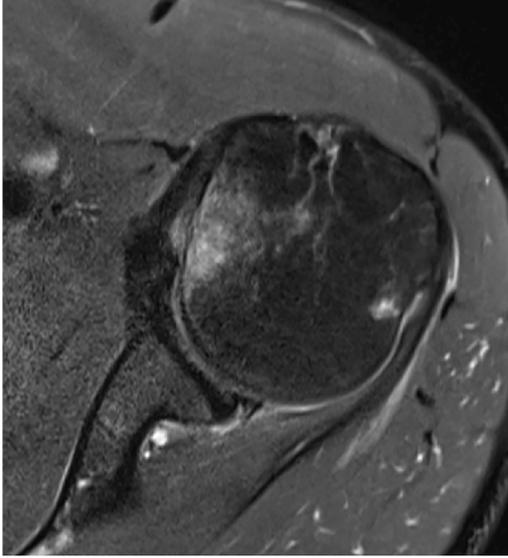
Axial T2 MRI showing posterior labral tear and anterior humeral head impaction consistent with a dislocation event.
